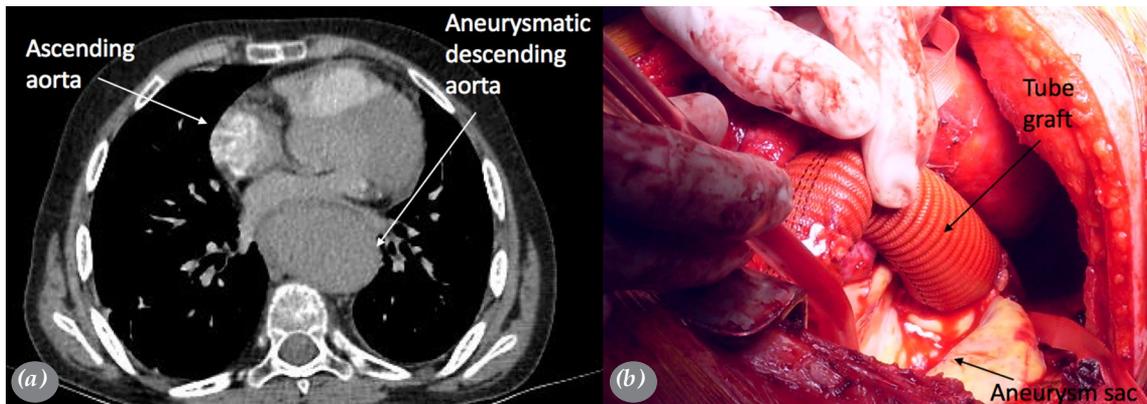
(a) The descending aortic aneurysm is observed on CTA performed before the first operation. (b) The image of the repairing the previous descending aortic aneurysm with the tube graft interposition.
